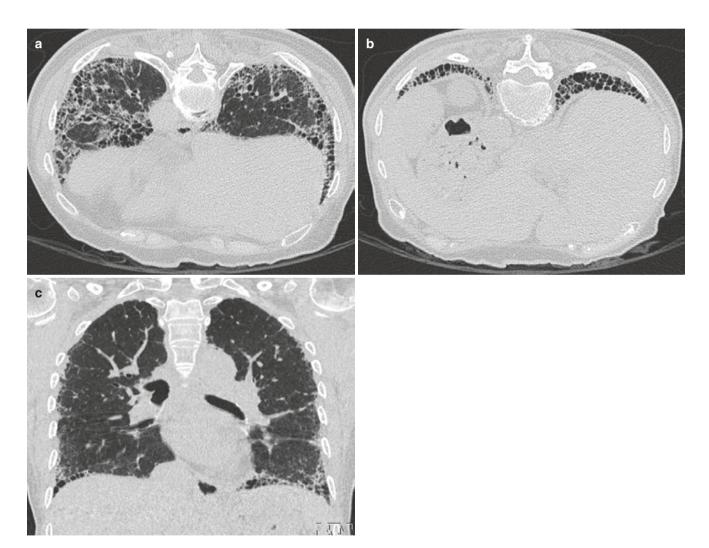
Typical UIP. (a, b) Axial prone CT images show peripheral predominant reticular opacities, honeycombing with traction bronchiectasis. (c) Coronal CT image shows lower lung predominance
